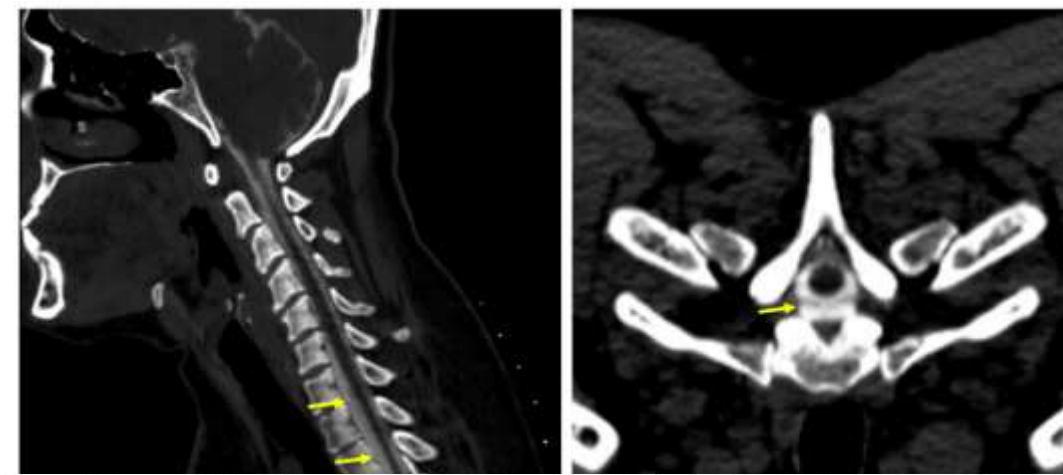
Dynamic CT Myelogram of the spine shows the 'double density sign' (yellow arrows) which is suggestive of CSF leak.
